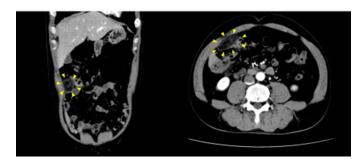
Contrast-enhanced CT scan one week after the first examination. The left side is a coronal slice image, and the right side is a horizontal image. Compared with the initial CT image, the density of the fat tissue in the mass had decreased and the range had diminished (yellow triangle). Ascites was not detected.
